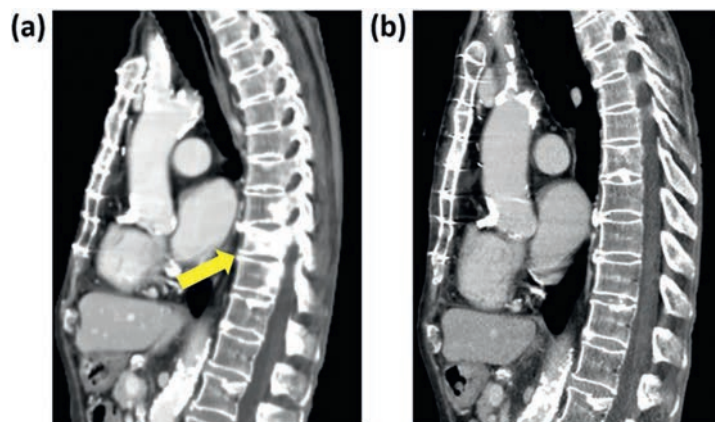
Radiological assessment of pleural metastases. (a–c) Computed tomography images of the thorax are shown. Yellow arrows indicate pleural foci. (a) Identification of pleural foci upon presentation to centre in April 2019. (b) Progressive disease after 3 months of cetuximab treatment in September 2019. (c) Complete radiological remission of foci after 10 months of cemiplimab treatment in August 2020.
